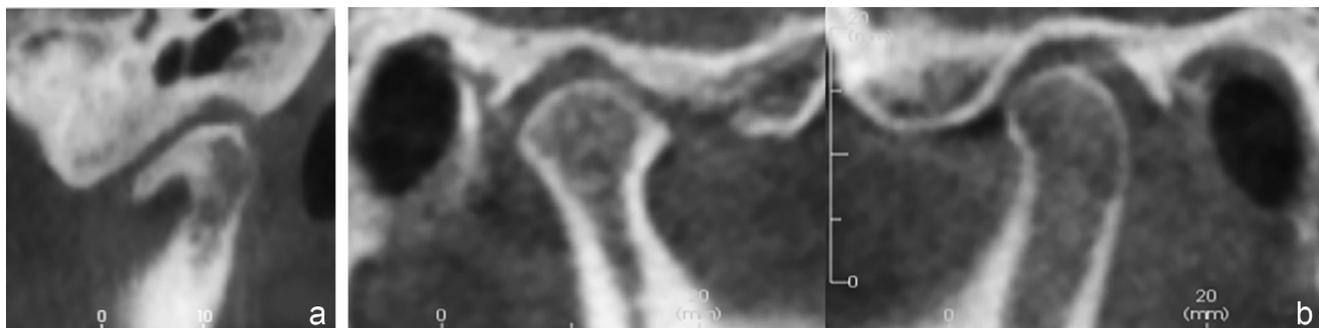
CBCT cross sections show the appearance of stable end-stage degenerative joint disease for (a) adult degenerative joint disease and (b) juvenile degenerative joint disease (idiopathic condylar resorption) on the right compared to the normal left side.
